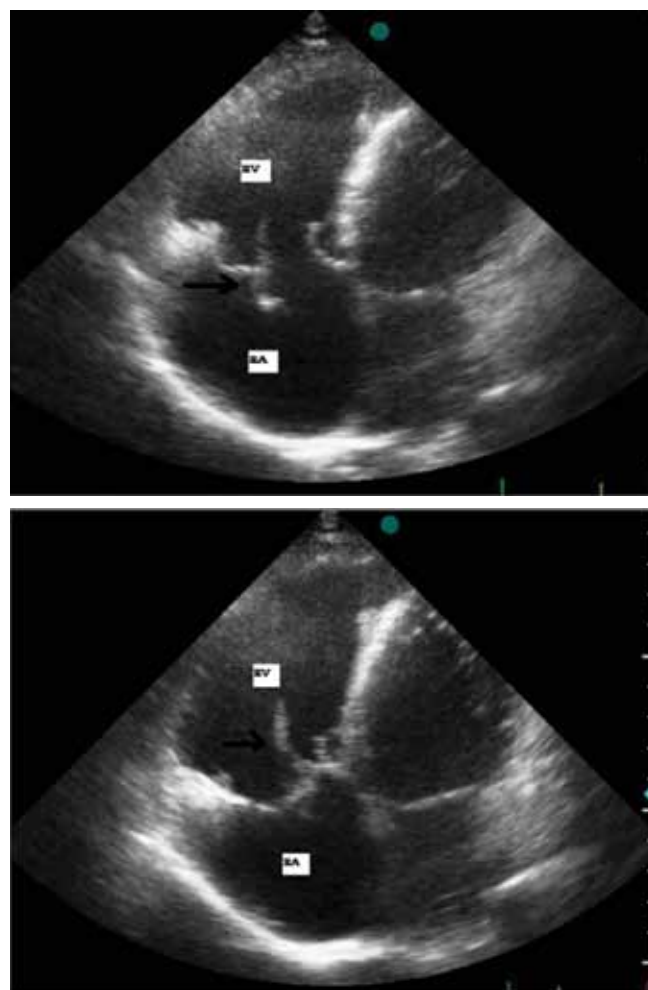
Apical four-chamber view showing a prolapse of the anterior leaflet. RV: right ventricle, RA: right atrium.
